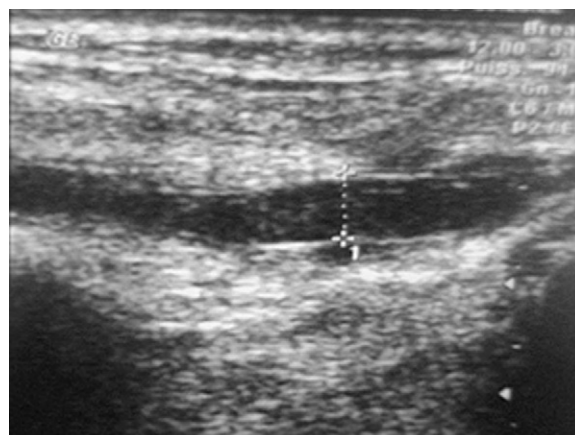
Echo Doppler shows aneurysm of right anterior tibial arteries.
